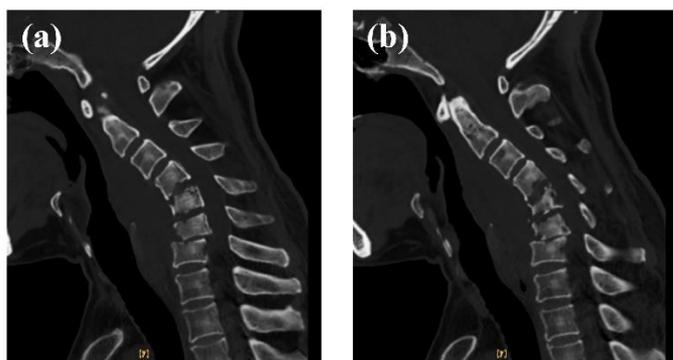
CT shows: 1. Soft tissue mass shadow can be seen in the cervical spine, and bone destruction in different degrees can be seen in the C4-7 vertebral body. The C5-6 vertebral body is unstable and dislocated, considering infection and abscess formation. 2. Cervical reverse arch deformity.
